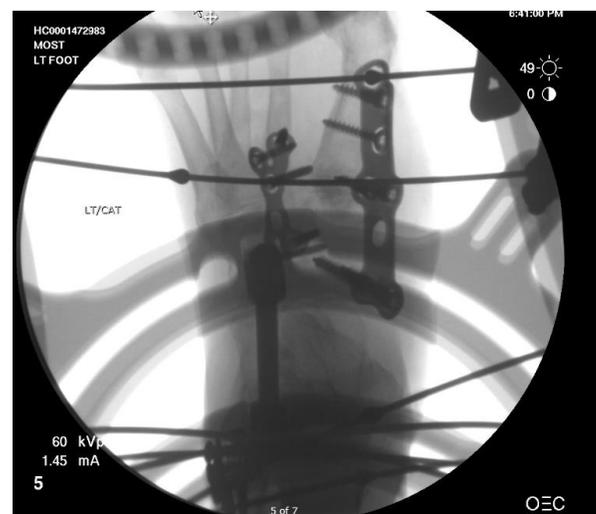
Postoperative radiograph of the left foot with a Salvation 3Di plate from Wright Medical along the medial column, a 2-hole Beta MAXLOCK Extreme plate from Wright medical and a 160 mm Salvation external fixator from Wright Medical
